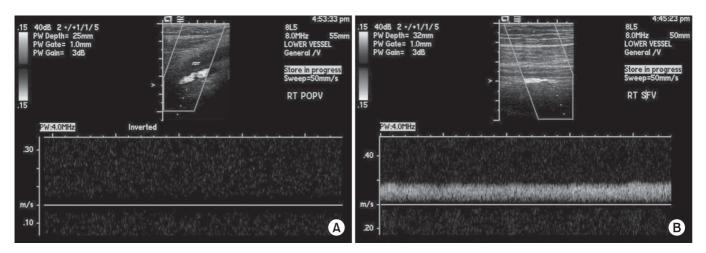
(A) Doppler ultrasonography (US). Uncompressed distal superficial femoral and popliteal veins with internal iso- to hyperechoic material. (B) No blood signal or flow was detected on Doppler US, suggesting a deep vein thrombosis.
